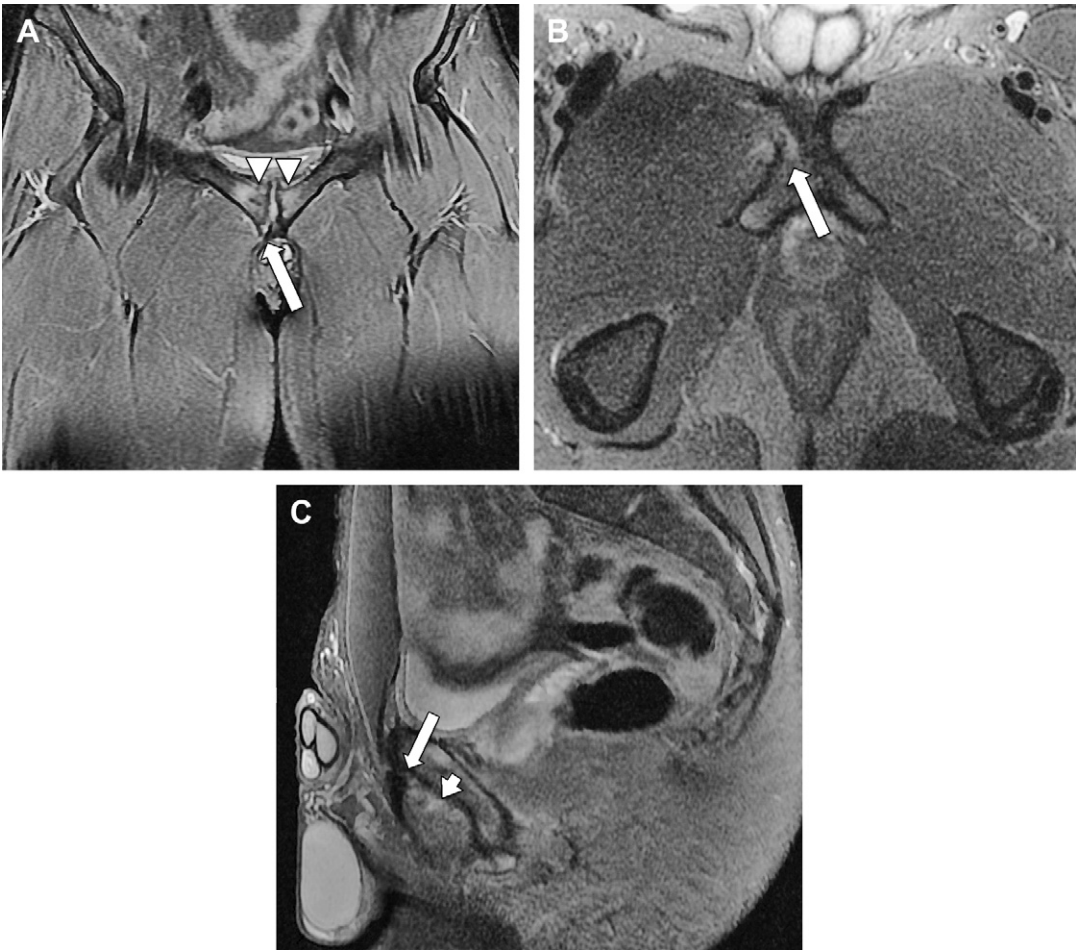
(A) Coronal fat-saturated T2-weighted MR image. Bilateral osteitis pubis, right worse than left, characterized by bone marrow hyperintensity (arrowheads), with microtearing along the medial right obturator externus attachment and disruption of the prepubic aponeurotic complex causing secondary cleft formation (straight arrow). (B) Axial fat-saturated T2-weighted MR image demonstrating microtearing of the right obturator externus attachment posterior to adductor longus with secondary bony stress reaction (arrow). (C) Sagittal fat-saturated T2-weighted MR image. Edema and microtearing of the origin of the obturator externus (short arrow) posterior to adductor longus and brevis, extending posterior to the adductor longus origin from the prepubic aponeurotic complex (long arrow).
